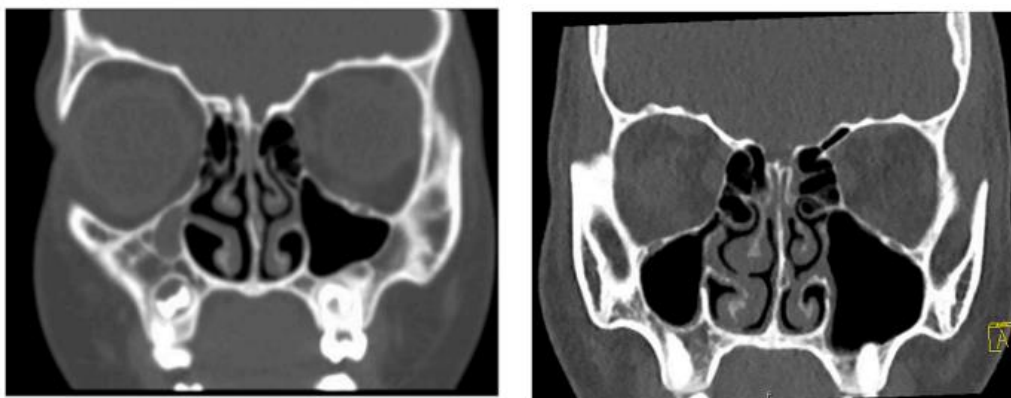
Computed Tomography (CT) Scan of Sinuses at Age 4 and 13 Years
